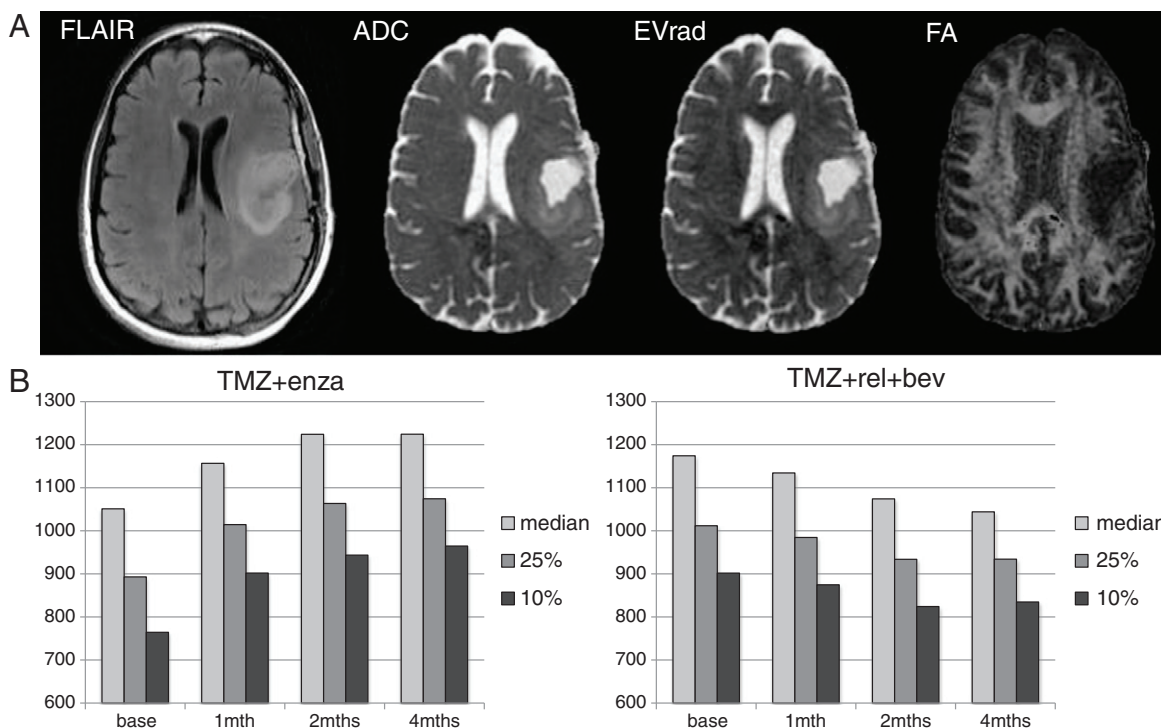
The baseline images (A) from the same patient as shown in Figure 5. FLAIR, ADC, EVrad, and FA. The bar plots in (B) show the time course of changes in ADC histogram percentiles for patients with all four scans. These demonstrate that the ADC increases for the TMZ+enza cohort and show a trend toward decreasing for the TMZ+erl+bev cohort.
